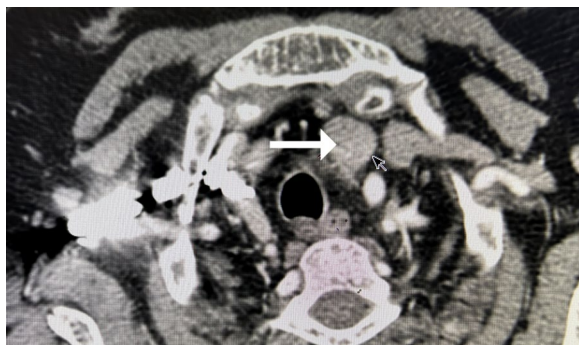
Contrast-enhanced computed tomography of neck. Axial Section Image of the same patient depicts a solitary, homogeneously enhancing nodule arising from the left inferior lobe of the parathyroid gland (white arrow)
